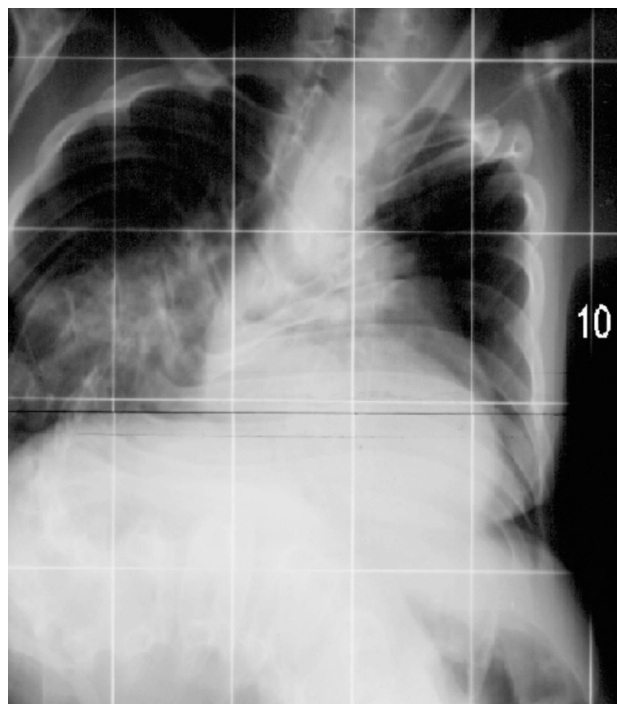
Anteroposterior spine radiograph showed severe thoraco-lumbar kyphoscoliosis.
